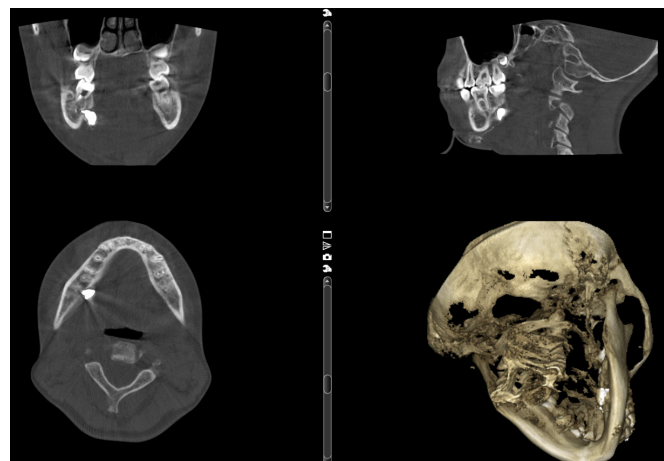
Cone-beam computed tomography showing a hyperdense lesion in the right mandible with surrounding bone necrosis
